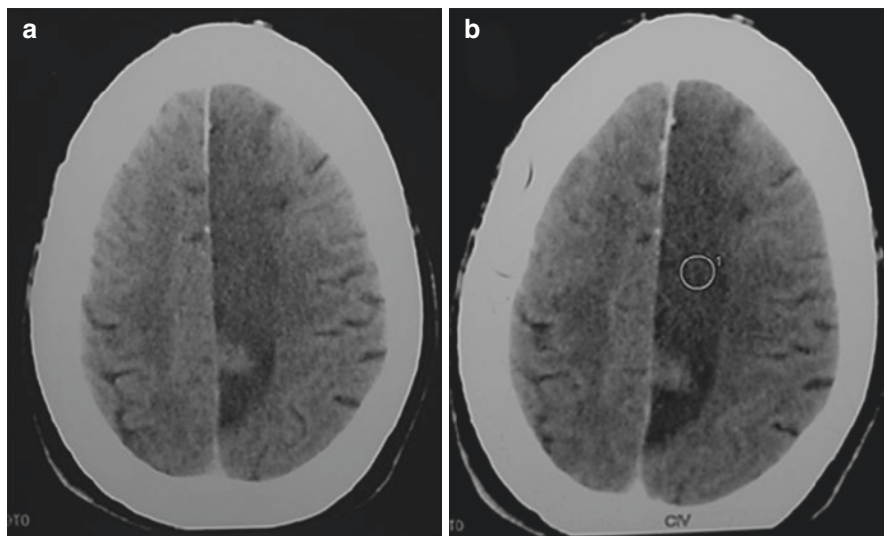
Cerebral CT scan in the axial plane before (a) and after (b) contrast showing a left interhemispheric CSDH
